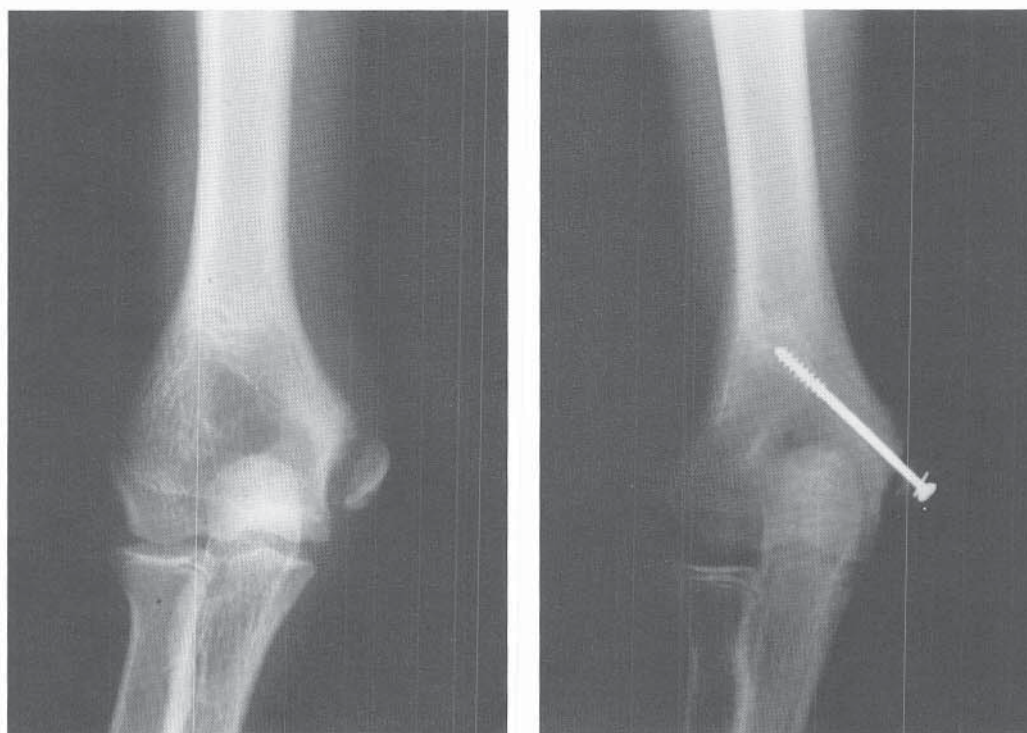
A, Displaced medial epicondyle fracture in a 14-year-old Little League pitcher. The injury was sustained during pitching. B, AP radiograph obtained after open reduction and fixation of the medial epicondyle fragment.
